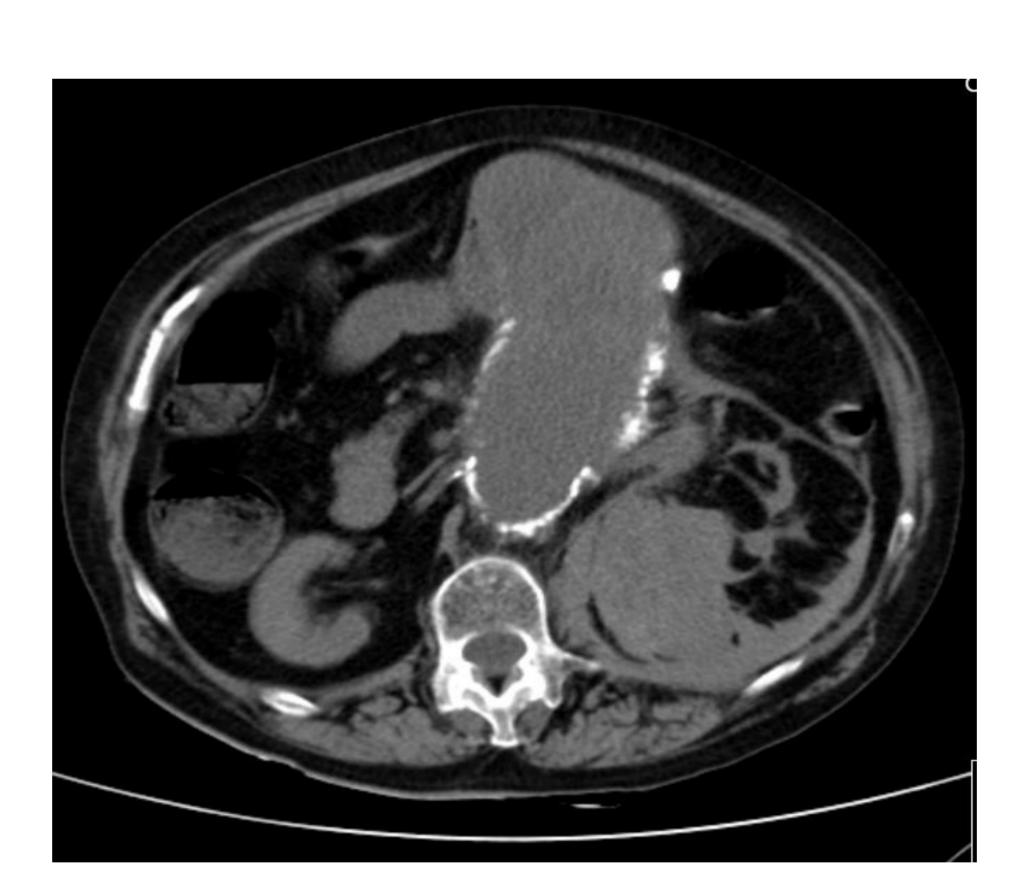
Thoracic-abdominal-pelvic computed tomography showing a large abdominal aortic aneurysm, reaching 14.24 cm in anteroposterior diameter. The left renal artery was leaving the aneurysm, which was in rupture and there was a massive retroperitoneal hematoma on the left.
